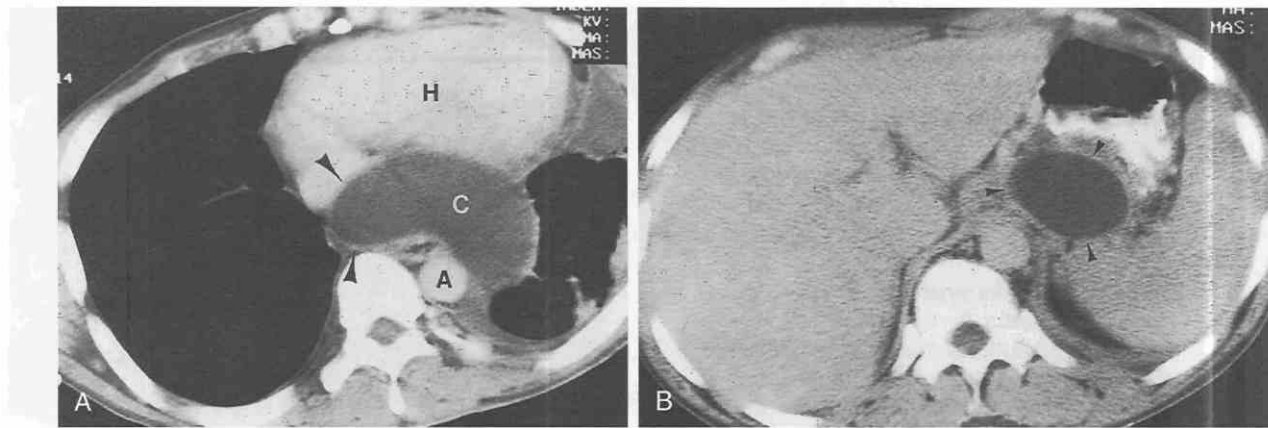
Mediastinal pseudocyst in a patient with chronic pancreatitis. A, Contrast-enhanced CT shows homogeneous water-attenuation mass (C) in the middle mediastinum with a thin enhancing rim (arrowheads). A small left pleural effusion can be seen. A, aorta; H, heart. B, A more caudal CT image confirms origination of mass (arrowheads) from the tail of the pancreas. (Case is courtesy of May Lesar, Bethesda, Md.)
